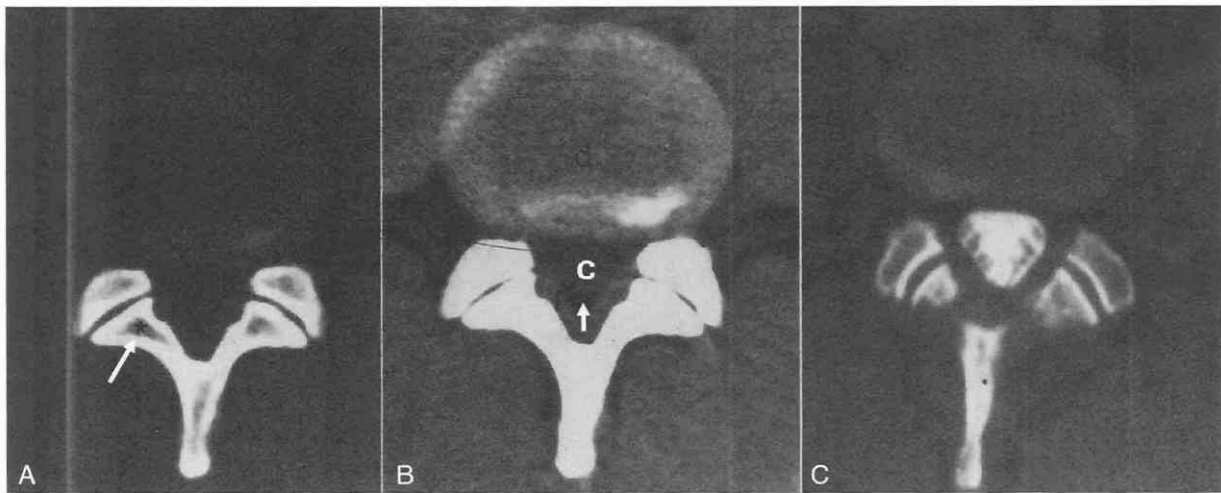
Axial CT scan using wide (bone) windows (W, 1450, L, 100) (A) and narrow (soft tissue) windows (W, 400; L, 40) (B). Bone detail is better on the wide window settings. The cortex (black arrow) and marrow (asterisk) can best be distinguished with wide windows. However, contrast between the disk (d), epidural fat (white arrow), ligamentum flavum (l), and canal (c) are best seen with narrow windows. C, Iohexol accentuates the contrast between the sac and the surrounding structures.
